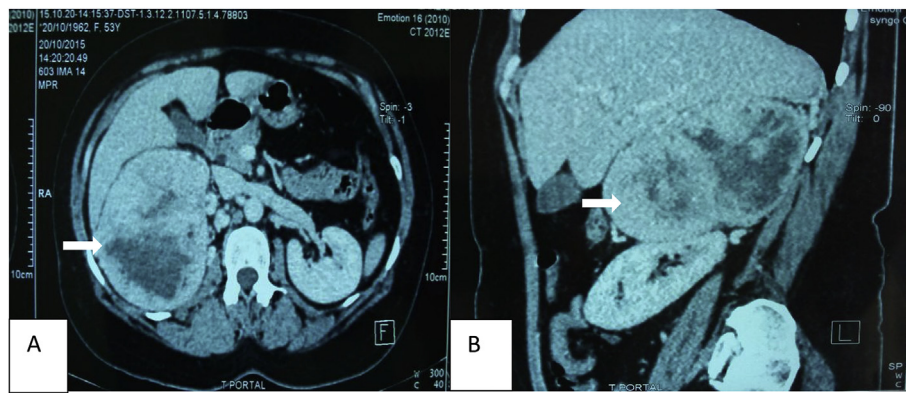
A: Axial contrast-enhanced CT image showing a circumscribed right adrenal mass with heterogeneous enhancement and a necrosis area (arrow) B: Sagittal contrast-enhanced CT scan demonstrating the repression of right kidney upper pole by the adrenal mass (arrow).
